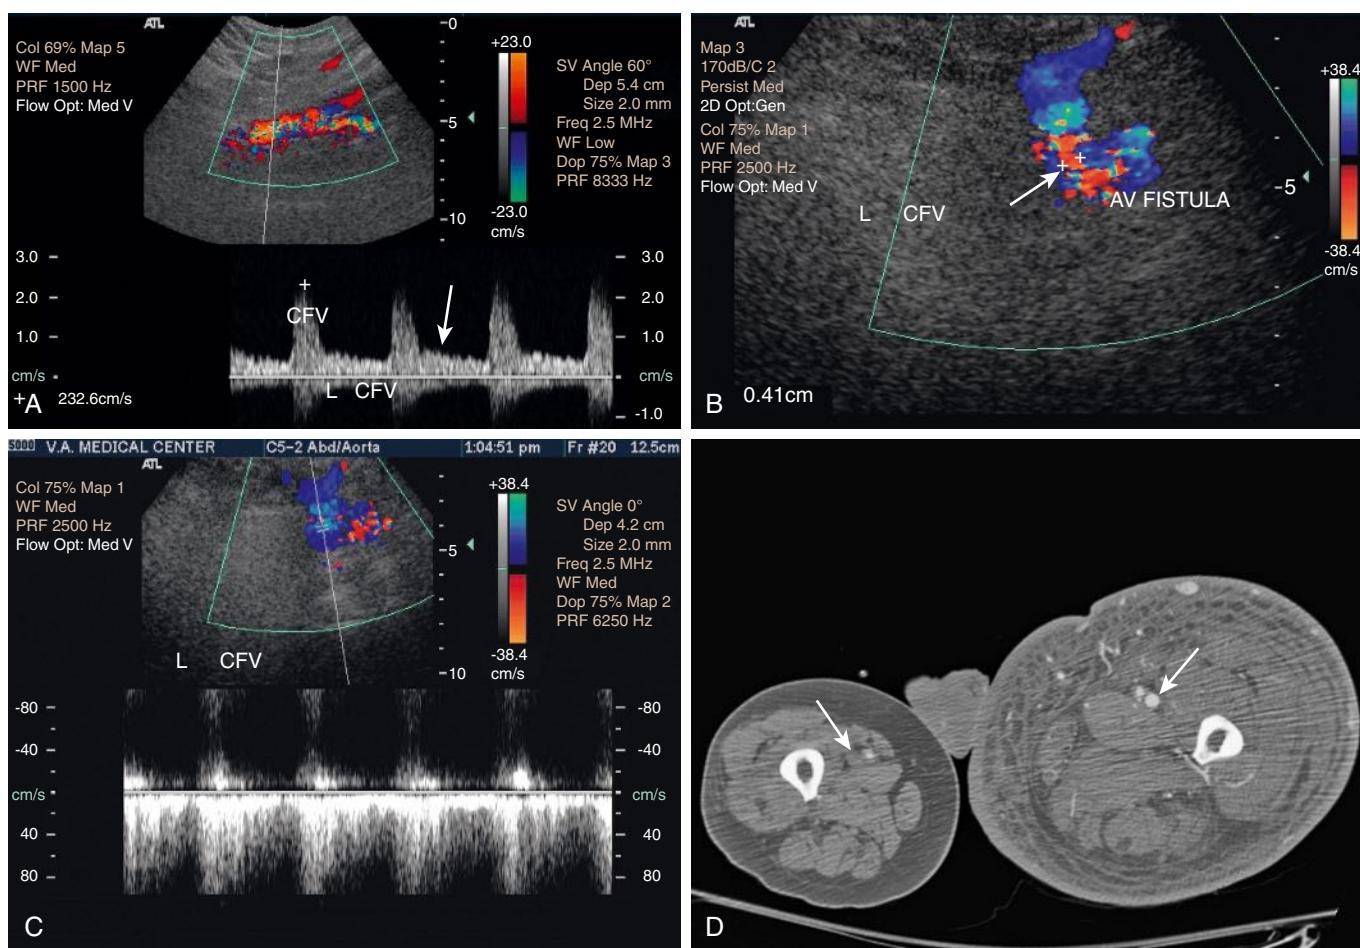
Ultrasound image and CT scan of a patient with a large common femoral AVF. Loss of triphasic waveforms with prolonged diastolic flow is observed in the common femoral artery (CFA) proximal to the fistula (A); a large connection is demonstrated by the white arrow between the CFA and common femoral vein (CFV) (B); pulsatile reversed flow is seen in the CFV distal to the fistula (arrow) (C); and early enhancement of superficial femoral vein (arrows) on the side with an AVF (D).
